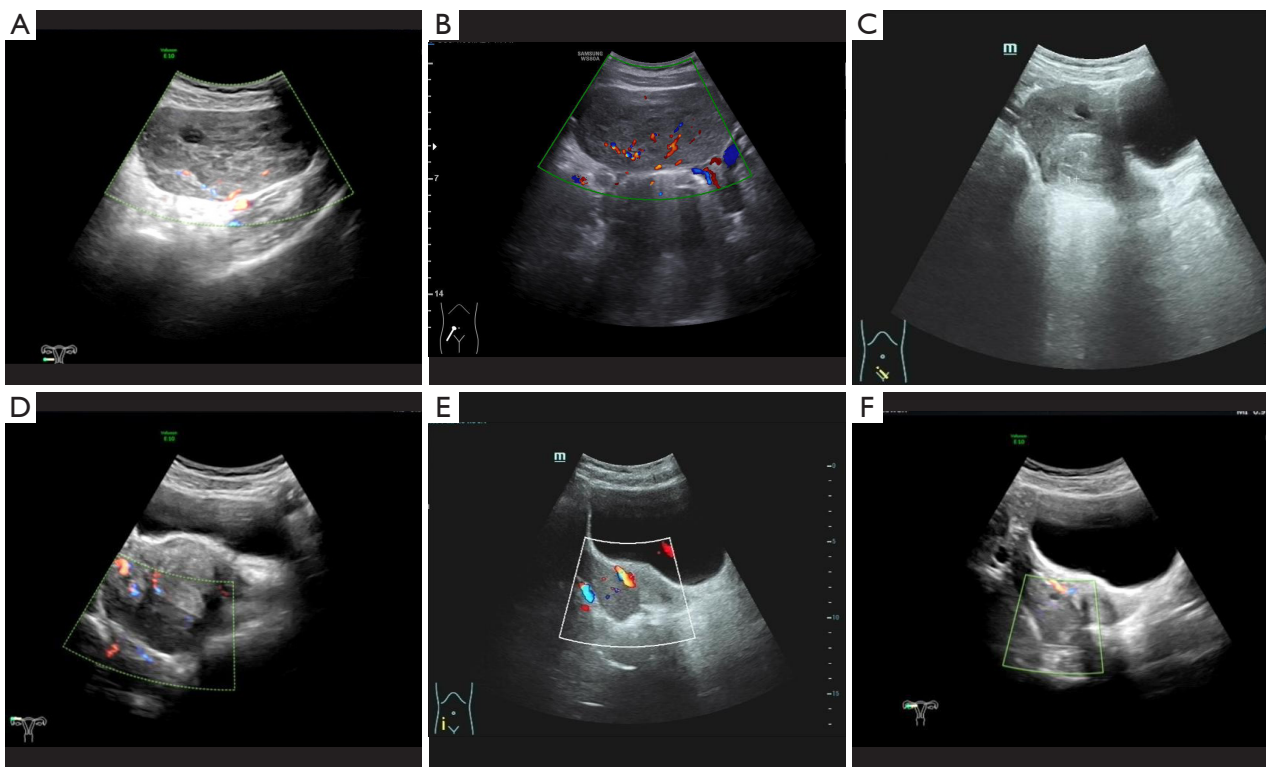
Results of routine ultrasound examinations during follow-up. The right adnexal mass was observed to shrink over time. The ultrasound times for the images above were as follows: 1 (A), 9 (B), 25 (C), 40 (D), 55 (E), and 70 d (F).
